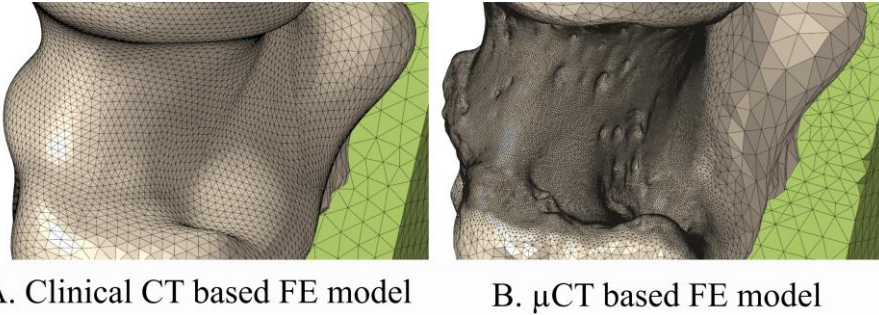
Meshes of the lateral neck of an FE model based on A) clinical CT images and B) μ CT images.
